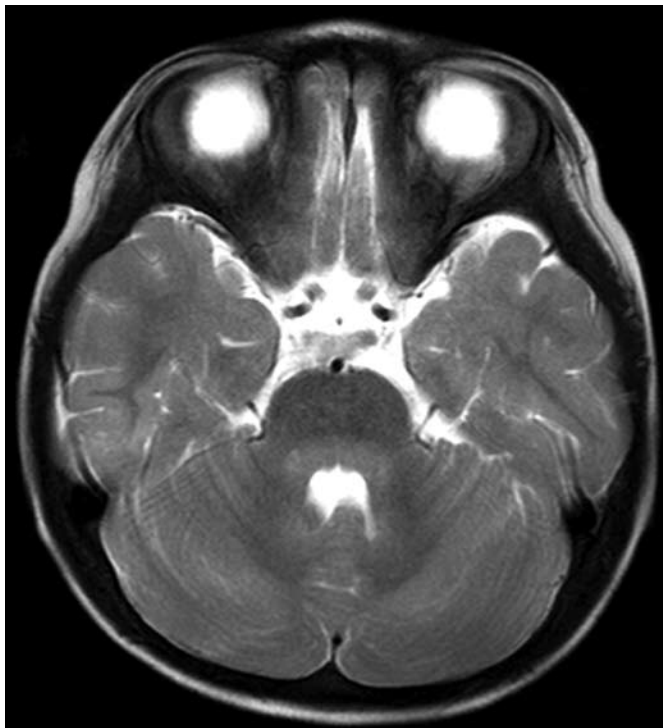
Axial T2-weighted slice of brain by magnetic resonance imaging, showing hyperintensity lesions in the pons and cerebellum around the fourth ventricle.
